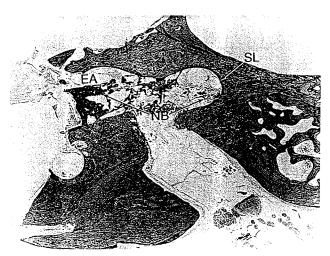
Basal turn near cochleostomy site of case 3, in which there was no clinical or radiographic evidence of new bone formation before operation (original ×9). Electrode array (EA) can be seen entering scala vestibuli, and there is new bone formation (NB) in scala tympani and scala vestibuli. In addition, there is trauma to spiral ligament (SL).
